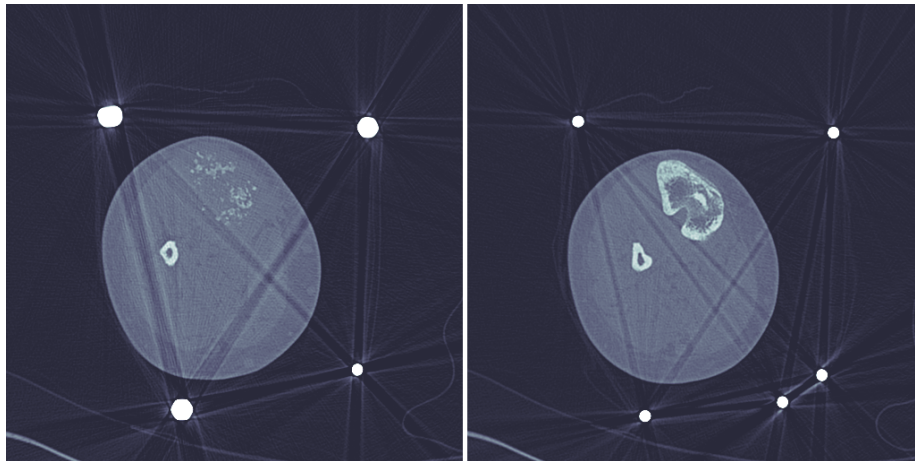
Metal artifacts in the CT scans of the callus distraction (left) and the reference section (right).
